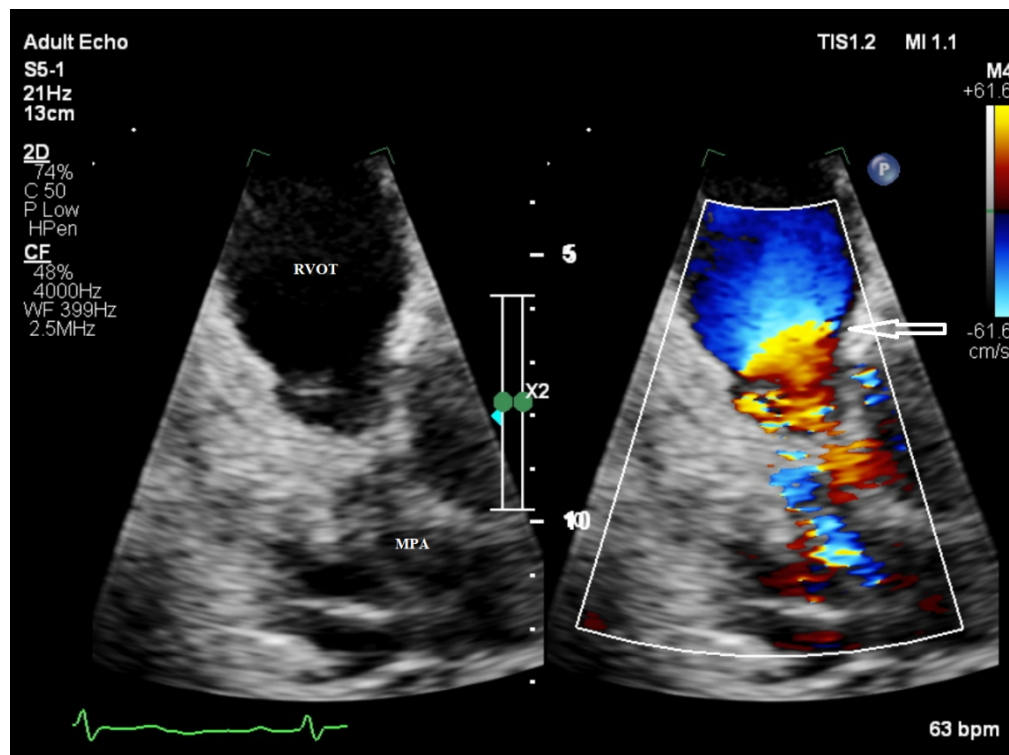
Tilted parasternal long axis view from a transthoracic echocardiogram using 2D (left panel) and colour Doppler (right panel) in a side-by-side format to demonstrate flow acceleration (indicated by the arrow) through fixed, retracted pulmonary valve leaflets, with the branch pulmonary arteries at the bottom of the image. RVOT=right ventricular outflow tract; MPA=main pulmonary artery.
